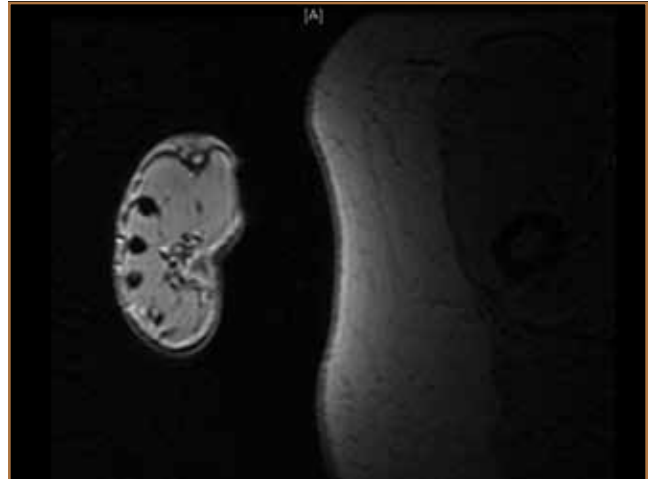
Scout MRI shows arm in neutral position at patient's side.
